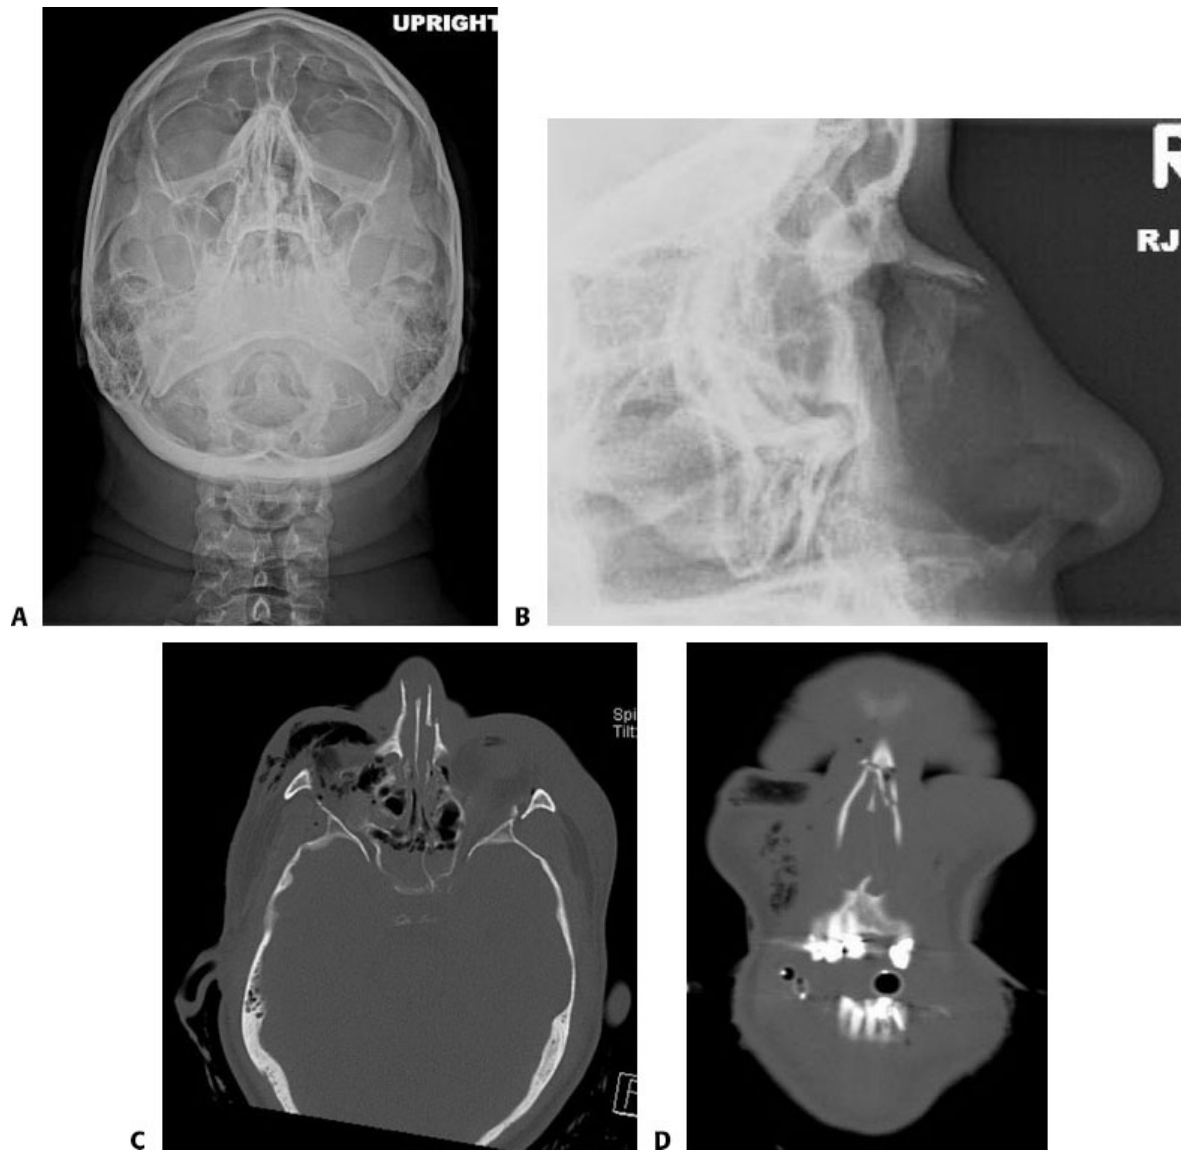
• A. Waters view of a patient with nasal trauma. No definitive fracture was identified by radiological exam; however, by clinical exam, the patient had obvious nasal deformity with deviation of the dorsum to the right. B. Lateral radiograph of the same patient demonstrating no definite fracture. Nonspecific irregularity of the tip of the nasal bone was noted. In a different patient, axial (C) and coronal (D) CTs demonstrate a displaced left nasal bone fracture.
